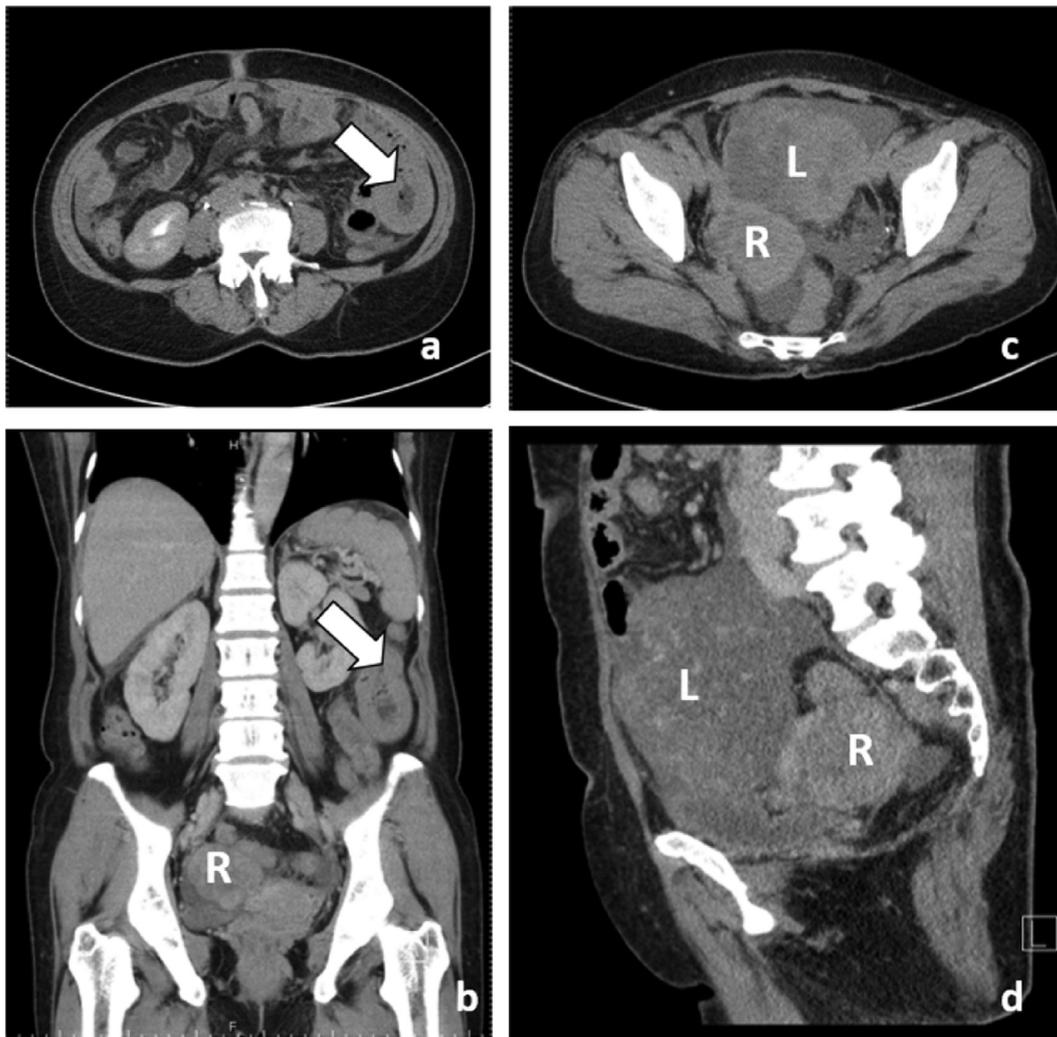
Computed tomography scan (a) A segmental wall thickening mass of the jejunum, about 3 cm in size (arrow); (b) (coronal view) jejunal mass (arrow) and right pelvic mass (R); (c) bilateral tumors consisting of solid and cystic components, left adnexal mass: 15 cm in size (L) and right adnexal mass: 7 cm in size (R) (d) (sagittal view) left adnexal mass (L) and right adnexal mass (R).
